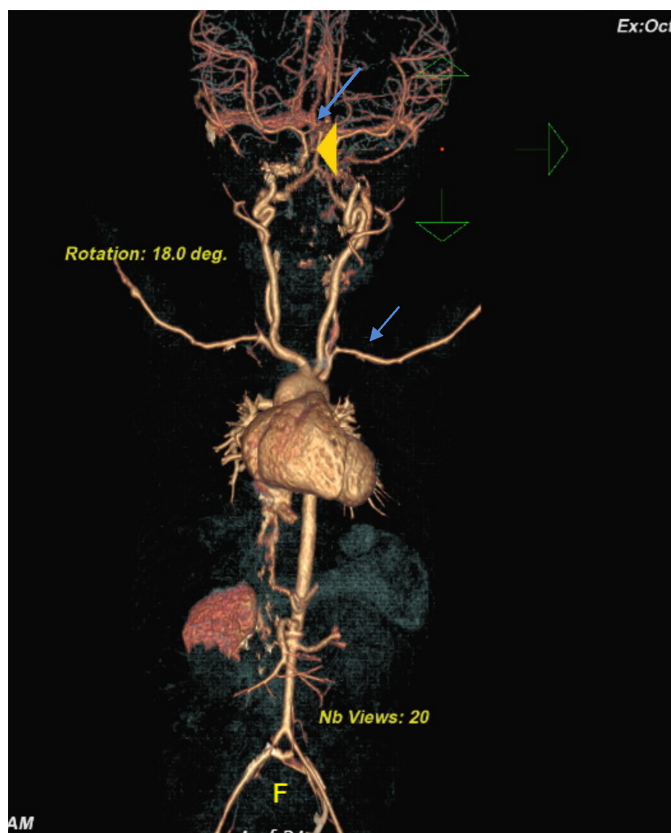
Post-treatment follow-up CT-angiogram showing reduction in the size of systemic artery aneurysms.
